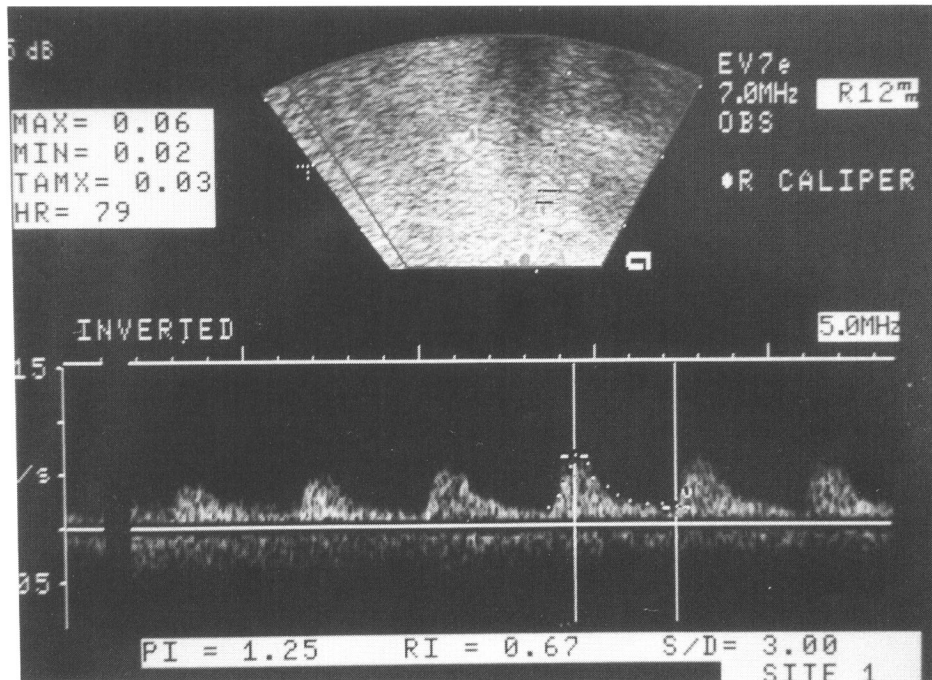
Adenomyosis had a higher PI and RI and a lower TAMXV of intratumoral vessels than those of outer feeding vessels of leiomyoma (by color Doppler energy).
